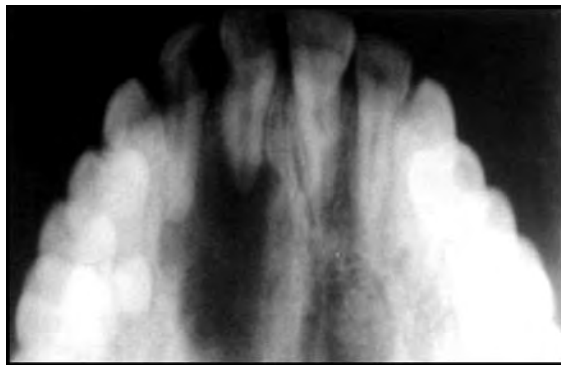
Occlusal view of the maxillary arch to access the extent of the periapical pathology
